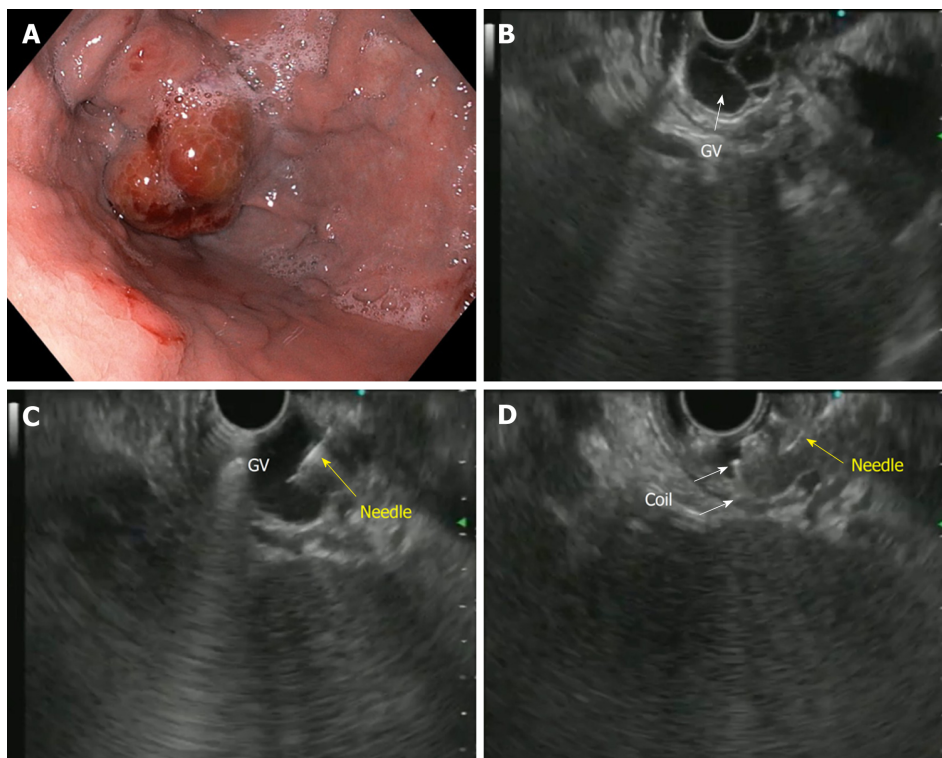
Endoscopic ultrasound-guided coil embolization of fundal varix. A: Endoscopic view of the fundal varix; B: Endoscopic ultrasound (EUS) view of the fundal varix; C: EUS guided puncture of the varix with a 22-G needle; D: Coil deployment inside the varix. GV: Gastric varices.
